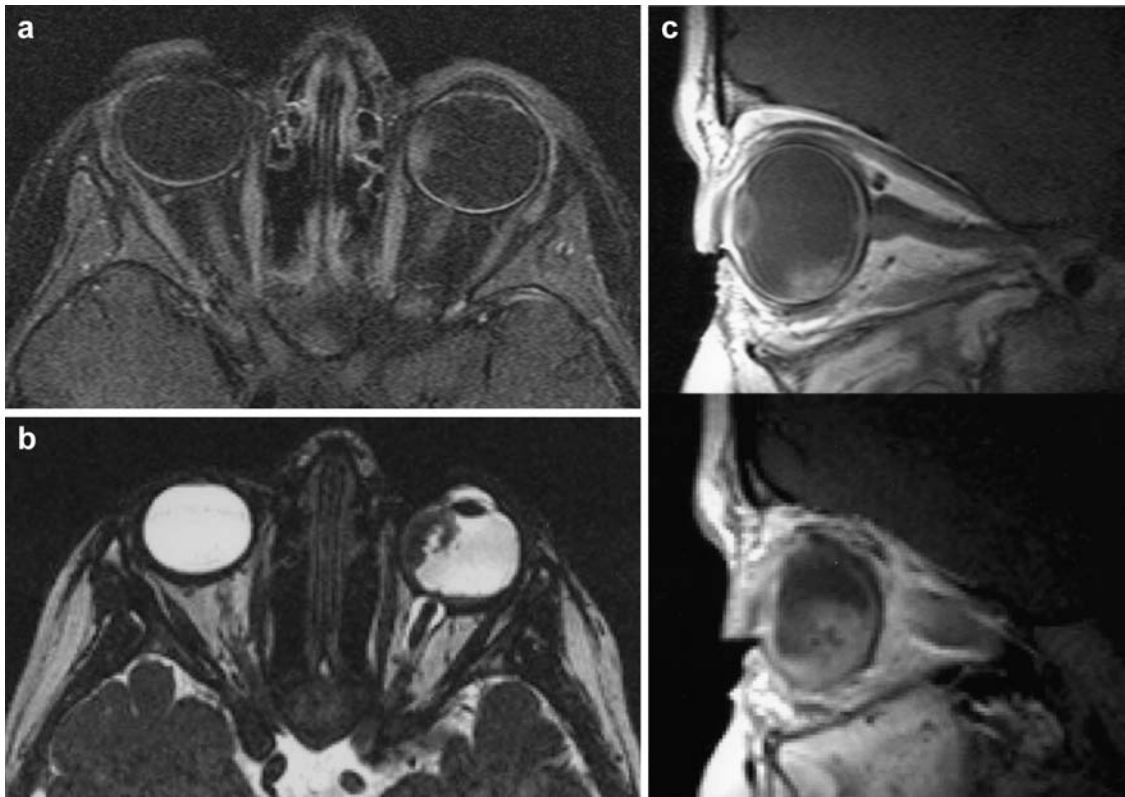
A 53-month-old boy with unilateral retinoblastoma of the left eye: comparison of head coil, small loop coil and CISS sequence. a Transversal high-resolution T1-weighted fat sat sequences after gadolinium application using a standard head coil. b Transversal reconstructed CISS images. c High-resolution T1-weighted fat sat sequences after gadolinium application with parasagittal slice orientation using a small loop coil
